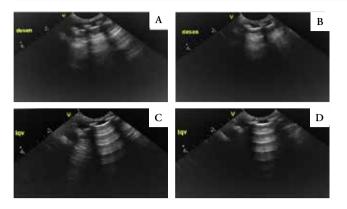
The Lung Ultrasound of Neonate 2 (A and C, right and left lungs, respectively) and Neonate 3 (B and D, right and left lungs, respectively)
